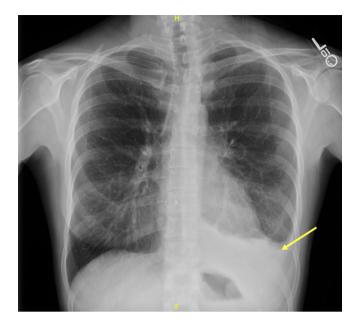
Post-PFO closure CXR. CXR showing a moderatelysized left pleural effusion (yellow arrow). CXR, chest radiograph; PFO, patent foramen ovale [Color figure can be viewed at wileyonlinelibrary.com]
